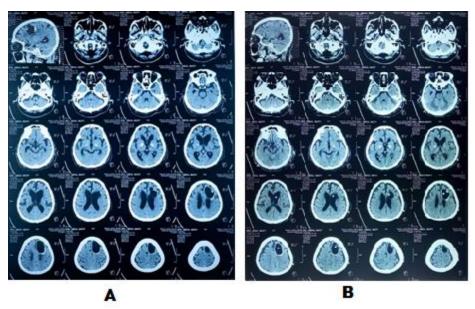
Case 2 of CT scan representation. (A) preoperative CT scan, (B) postoperative CT scan.
